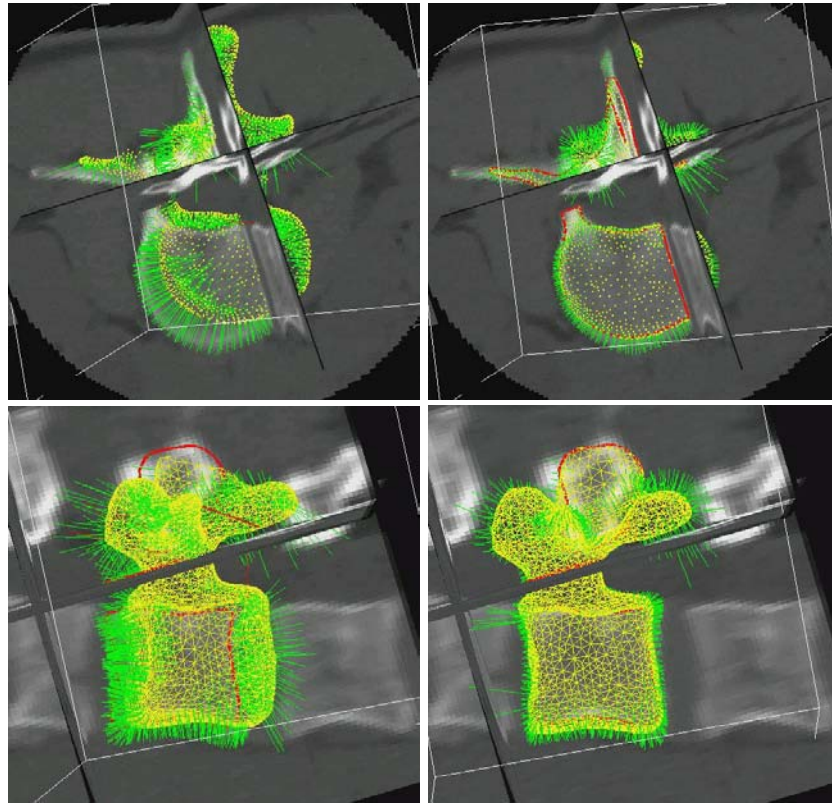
Rigid matching of the generic model with the CT exam (top axial view, bottom lateral view): after manual alignment (left), after automatic rigid registration (right)
